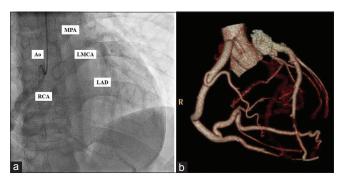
Coronary angiography (a) and computed tomographic angiography (b) showed a dilated and tortuous right coronary artery with retrograde filling of the left main coronary artery and main pulmonary artery through extensive posterior and apical collateralization
